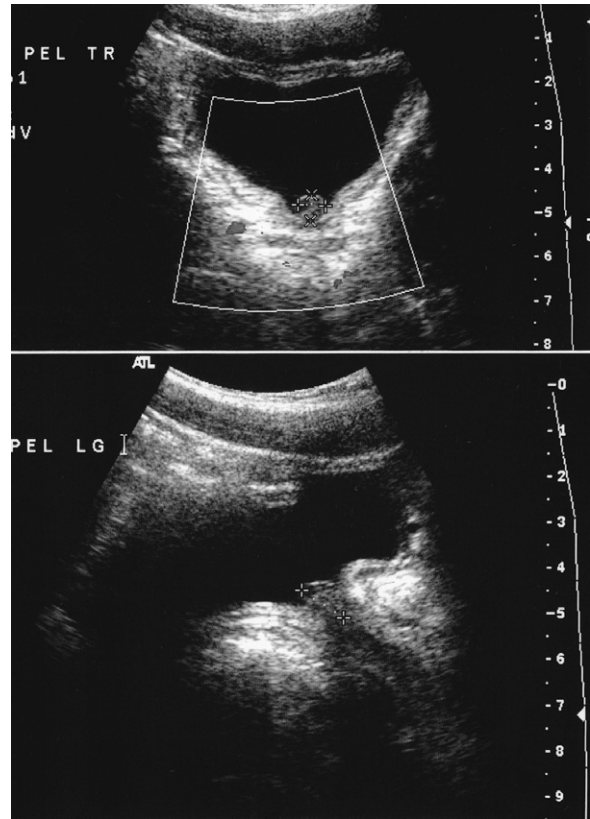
Posterior urethral polyp seen on ultrasound of bladder. Top view shows transverse image of bladder with polyp arising from urethra (cursors). Bottom view shows longitudinal view of bladder with polyp seen at entry to posterior urethra (cursors).
